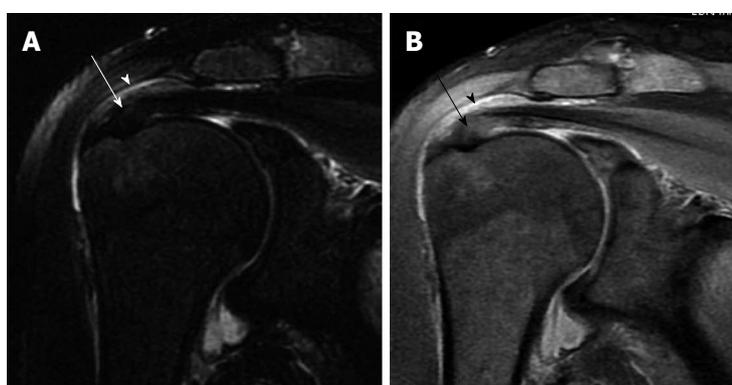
Subacromial impingement. A: Coronal oblique fat-sat T2-weighted image; B: Coronal oblique fat-sat proton-density-weighted image. Both images show findings associated with subacromial impingement in the form of osteoarthritis of the acromio-clavicular joint, distended subacromial subdeltoid bursa by fluid signal (arrowhead) and focal thickening of the distal supraspinatus tendon with partial irregularity of the bursal surface reported as partial tear (arrow).
